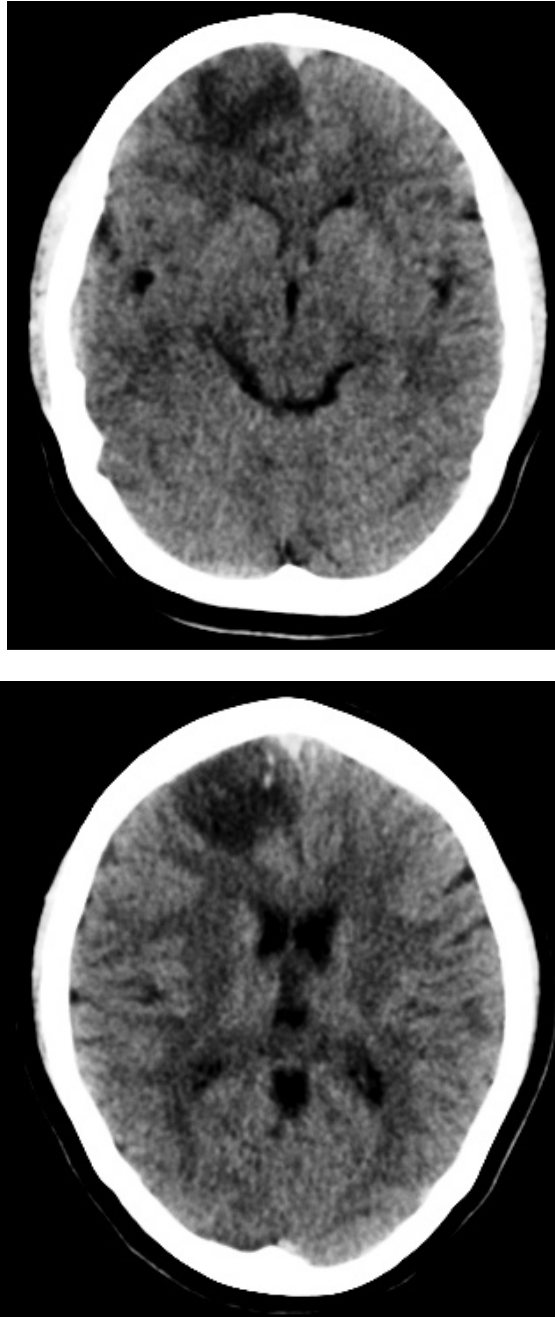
Figure – NE CT brain shows superior sagittal sinus thrombus with right frontal hemorrhagic infarct
